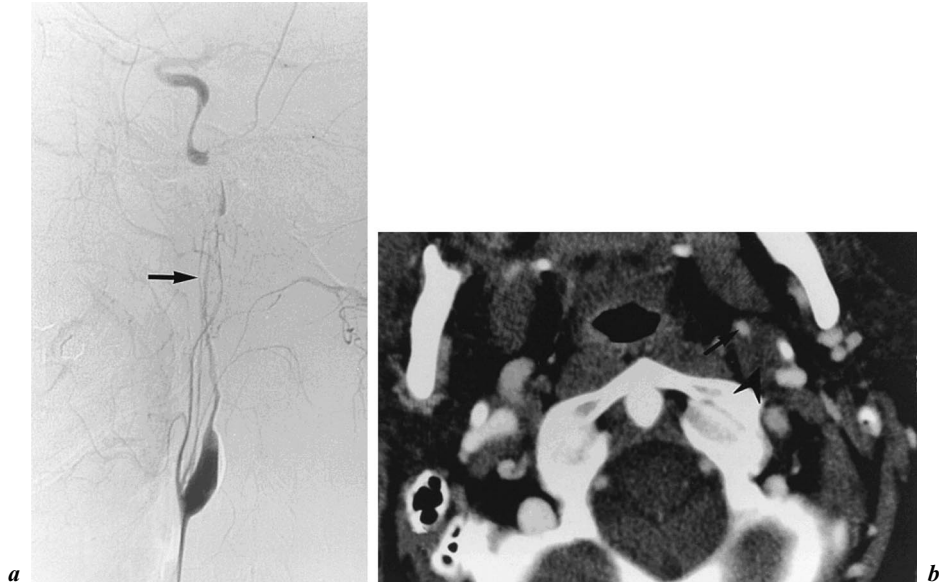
a* Left carotid artery dissection with tapered long stenosis on conventional angiography. *b* The external diameter of the carotid artery is enlarged on helical CT, and the arterial lumen appears eccentric (arrow) because of the arterial wall thickening (mural hematoma; arrowhead). The level of the CT slice is indicated on the angiogram (arrow; *a*).
